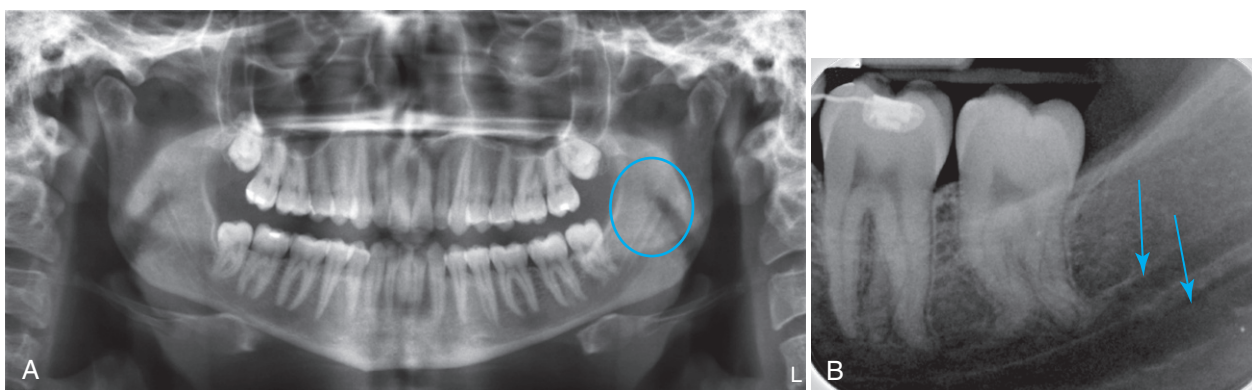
A, Panoramic radiograph image showing bifid inferior alveolar nerve IAN and canal. B, Periapical radiograph image confirming bifid IAN.
